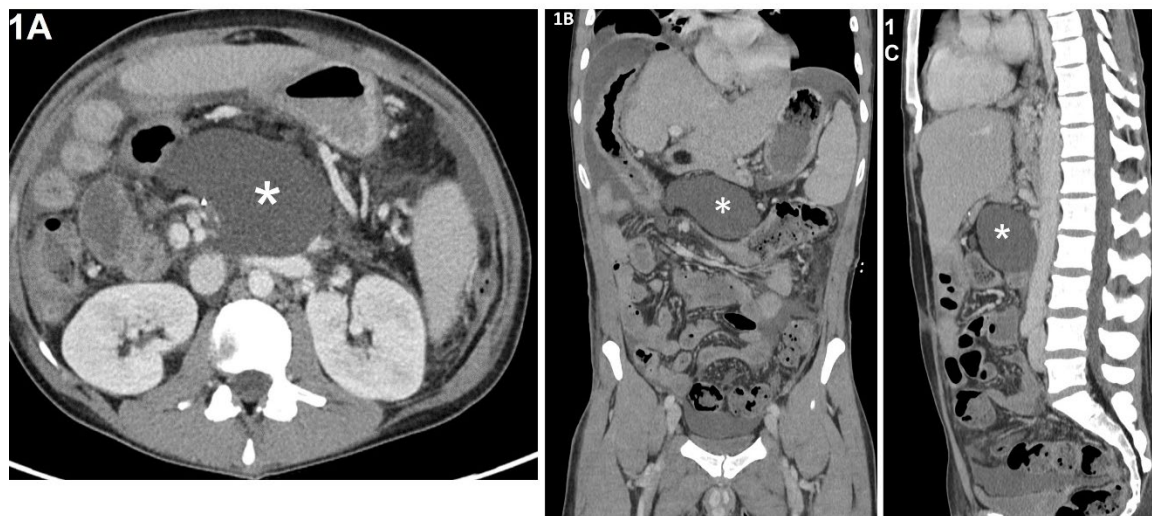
Computed tomography image showing the large central abdominal lymphocele (asterisk) in axial plane (A), coronal plane (B) and sagittal plane (C).
